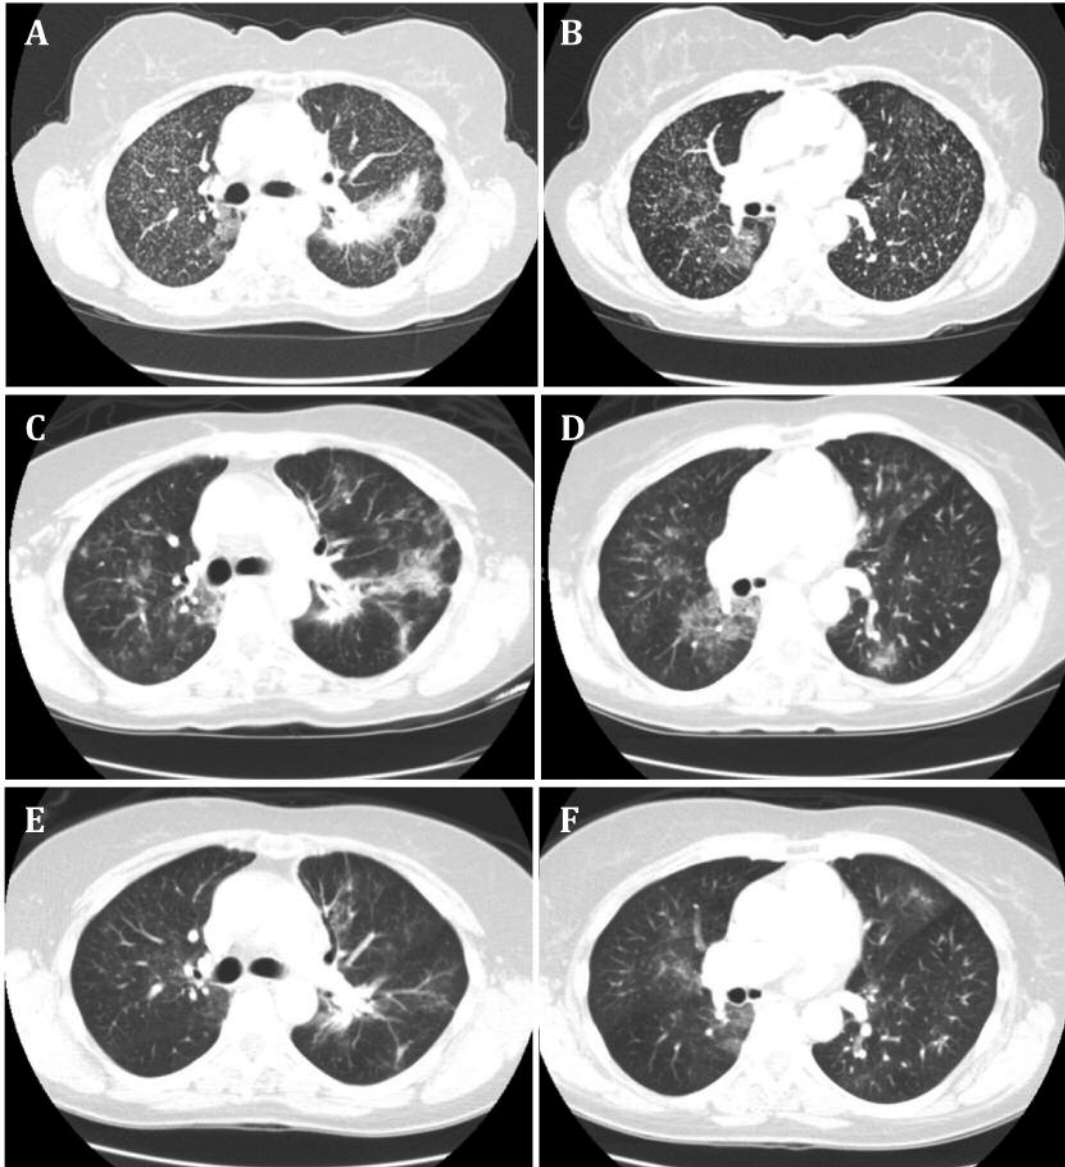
Chest CT of ground glass opacities. A chest CT performed prior to initiation of osimertinib with miliary type pattern metastases (A, B). A chest CT performed 3 months after initiation of osimertinib shows that the extensive miliary type pattern has largely resolved but now with patchy areas of ground glass infiltrate and intralobular septal thickening (C, D). Stable patchy ground glass infiltrates bilaterally on a chest CT 20 months after continued osimertinib use (E, F).
